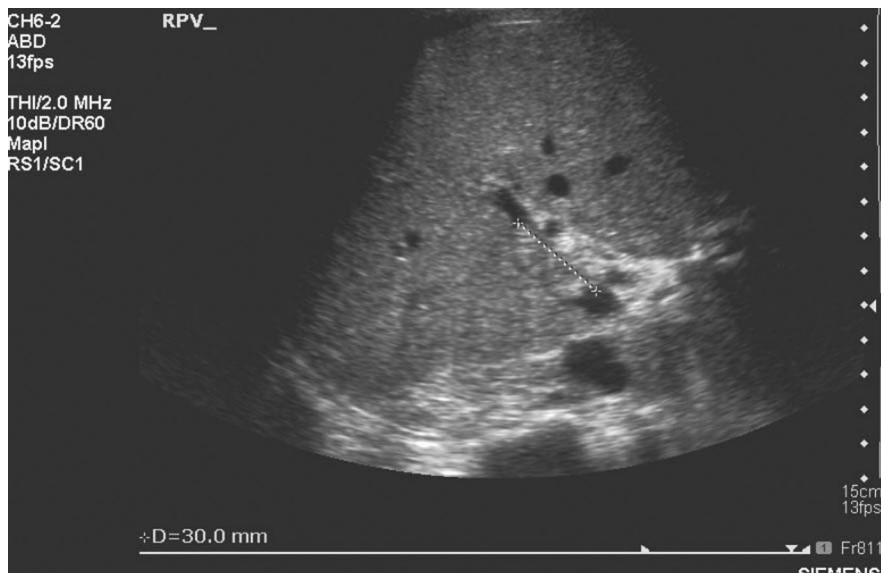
Hepatic ultrasound of the portal vein showing a 30 mm thrombus.
